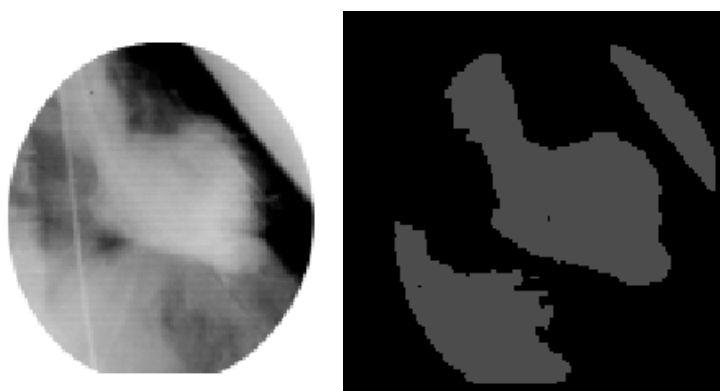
Segmentation of an MR image of the thorax.
